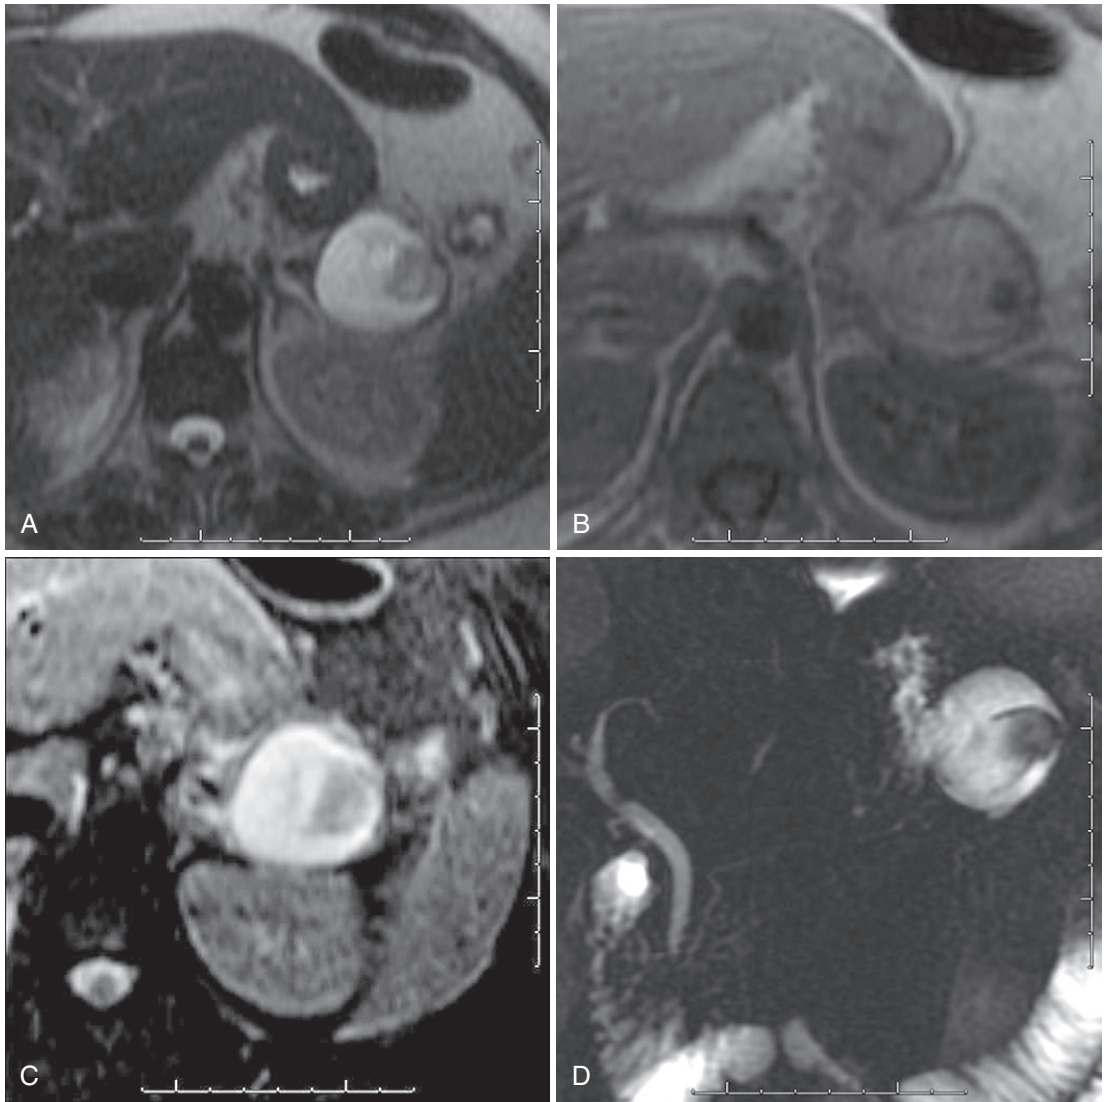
Mucinous cystic neoplasm. Mucinous cystic neoplasm of the pancreatic tail in a 47-year-old woman. T2-weighted (A), T1-weighted gradient recalled-echo (B), fat-suppressed T2-weighted (C), coronal thick-slab MIP MRCP (D), dynamic precontrast, early arterial phase (E), and late phase 3-D fat-suppressed T1-weighted gradient recalled echo (F and G), and coronal T2-weighted (H) images demonstrate a large cystic mass in the tail of the pancreas separate from the main pancreatic duct, with increased T1-weighted signal intensity (related to the mucin content) and minimal internal enhancement.
